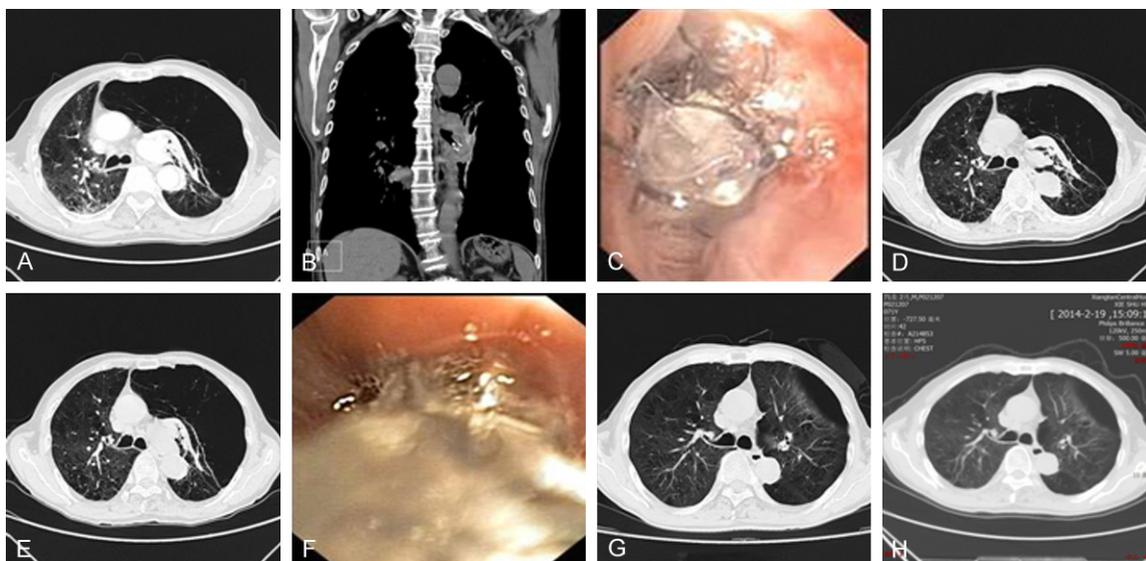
A: Chest CT showed a GBE occupying almost the left chest, together with compression atelectasis in adjacent pulmonary parenchyma. B and C: Chest CT and bronchoscopy showed that the Zephyr 4.0 EBV was positioned in the left lower lobe segmental bronchi; D and E: Chest CT showed partial volume reduction of the left lobe bullae with the mitigation of the mediastinal shift on d5 and d30 after EBV placement. F: Bronchoscopy displayed the ineffective EBV and abundant viscous secretion. G and H: Chest CT showed a marked volume reduction of the left lobe bullae with no mediastinal shift 7 months and 14 months after intracavitary drainage.
